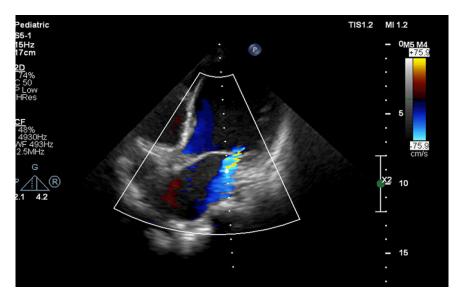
Echocardiograpic views showing left ventricular dialatation and dysfunction.
